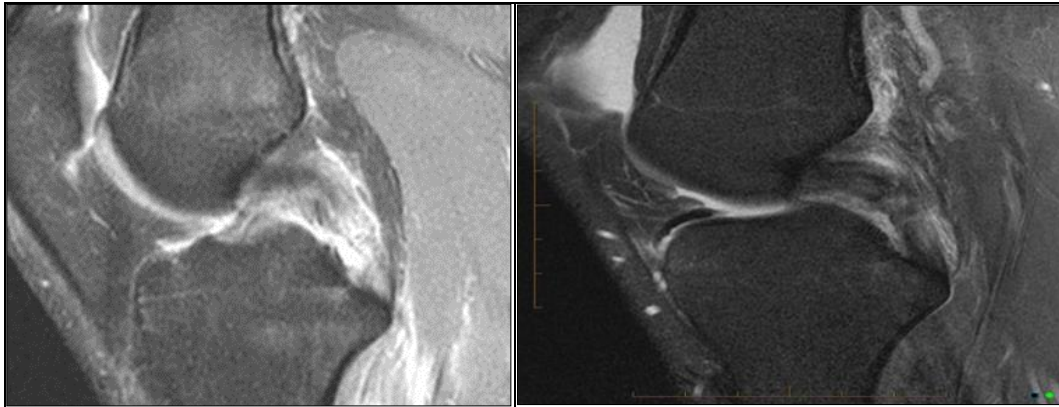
MRI T₂ weighted fat saturated images showing partial mid substance PCL tear
